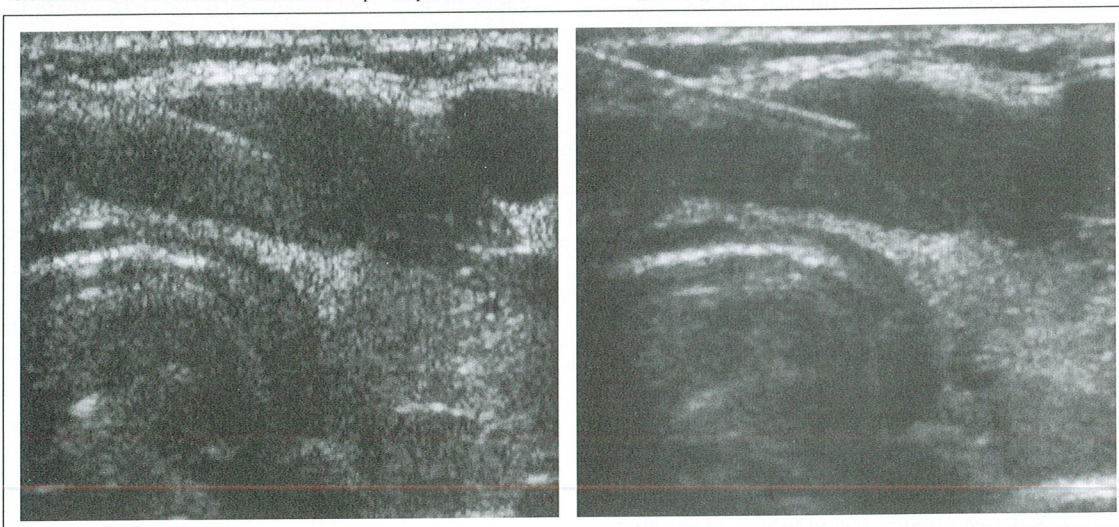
An isthmic nodule in a 37-year-old male. Compared to conventional sonography (a), compound sonography clearly improves the visualization of the needle shaft and tip (b).
